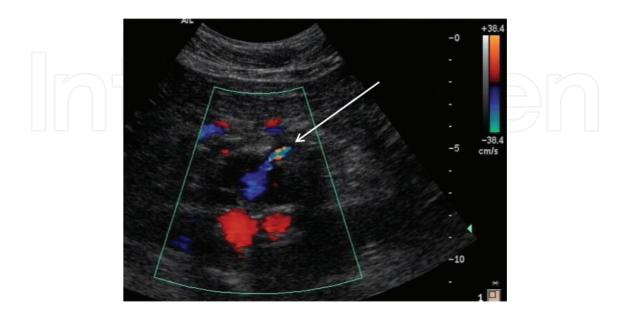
Duplex scan with color Doppler with endoleak type 2 via inferior mesenteric artery, marked by arrow.
